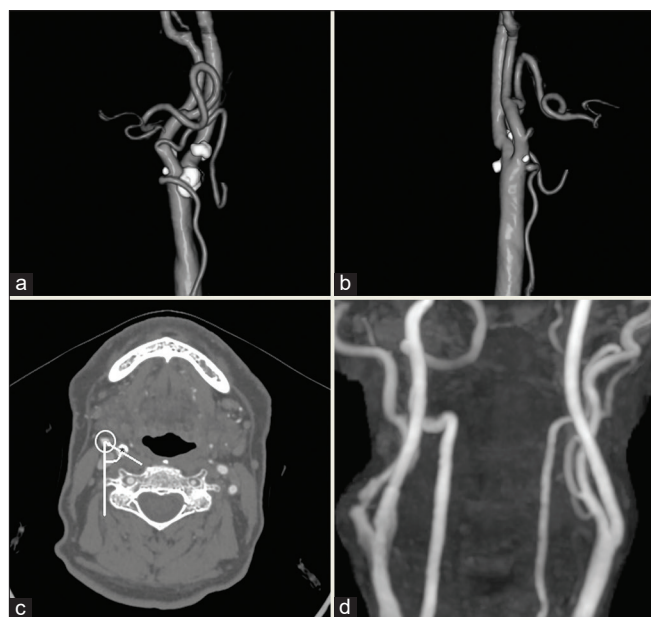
Computed tomography angiogram of the representative case 8: right carotid stenosis. (a) Preoperative anterior view showing that the internal carotid artery (ICA) runs medially, and the external carotid artery (ECA) runs laterally. The ECA branches cross-over the ICA. (b) Preoperative right lateral view showing the ICA coursing posteriorly to the ECA. (c) Twist angle measured in the axial view of computed tomography angiography as the medially deviated degree from the connected line (white line) of the centers of the ICA (asterisk) and the ECA (white circle) to the line parallel to the sagittal plane in the center of the ECA (thin white line). The preoperative twisted angle is 48°. (d) Postoperative magnetic resonance angiogram showing the dilated ICA without repositioning.
